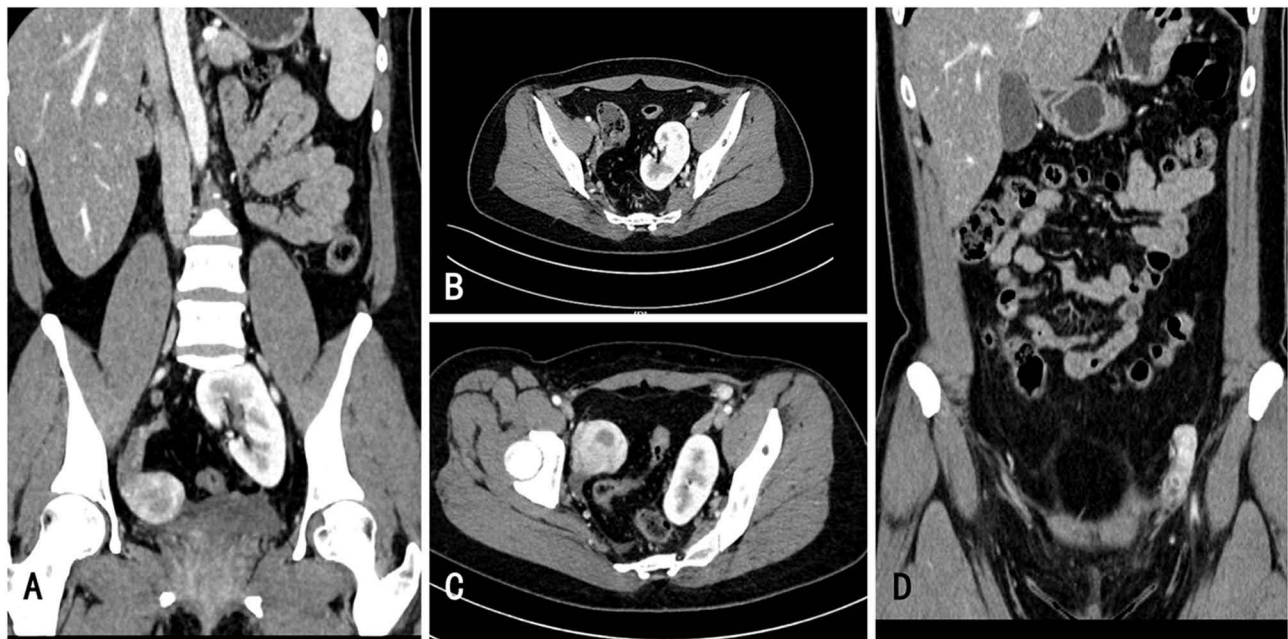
(A) Upright abdominal CT reconstruction showing an ectopic kidney located in the left pelvic cavity. (B) Three-dimensional CT reconstruction confirming the ectopic pelvic kidney on the left side. (C) Three-dimensional reconstruction of the abdominal CT image demonstrates a unicornuate uterus, a pelvic kidney, and inguinal-region contents. (D) Upright abdominal CT reconstruction depicting the inguinal region contents.
